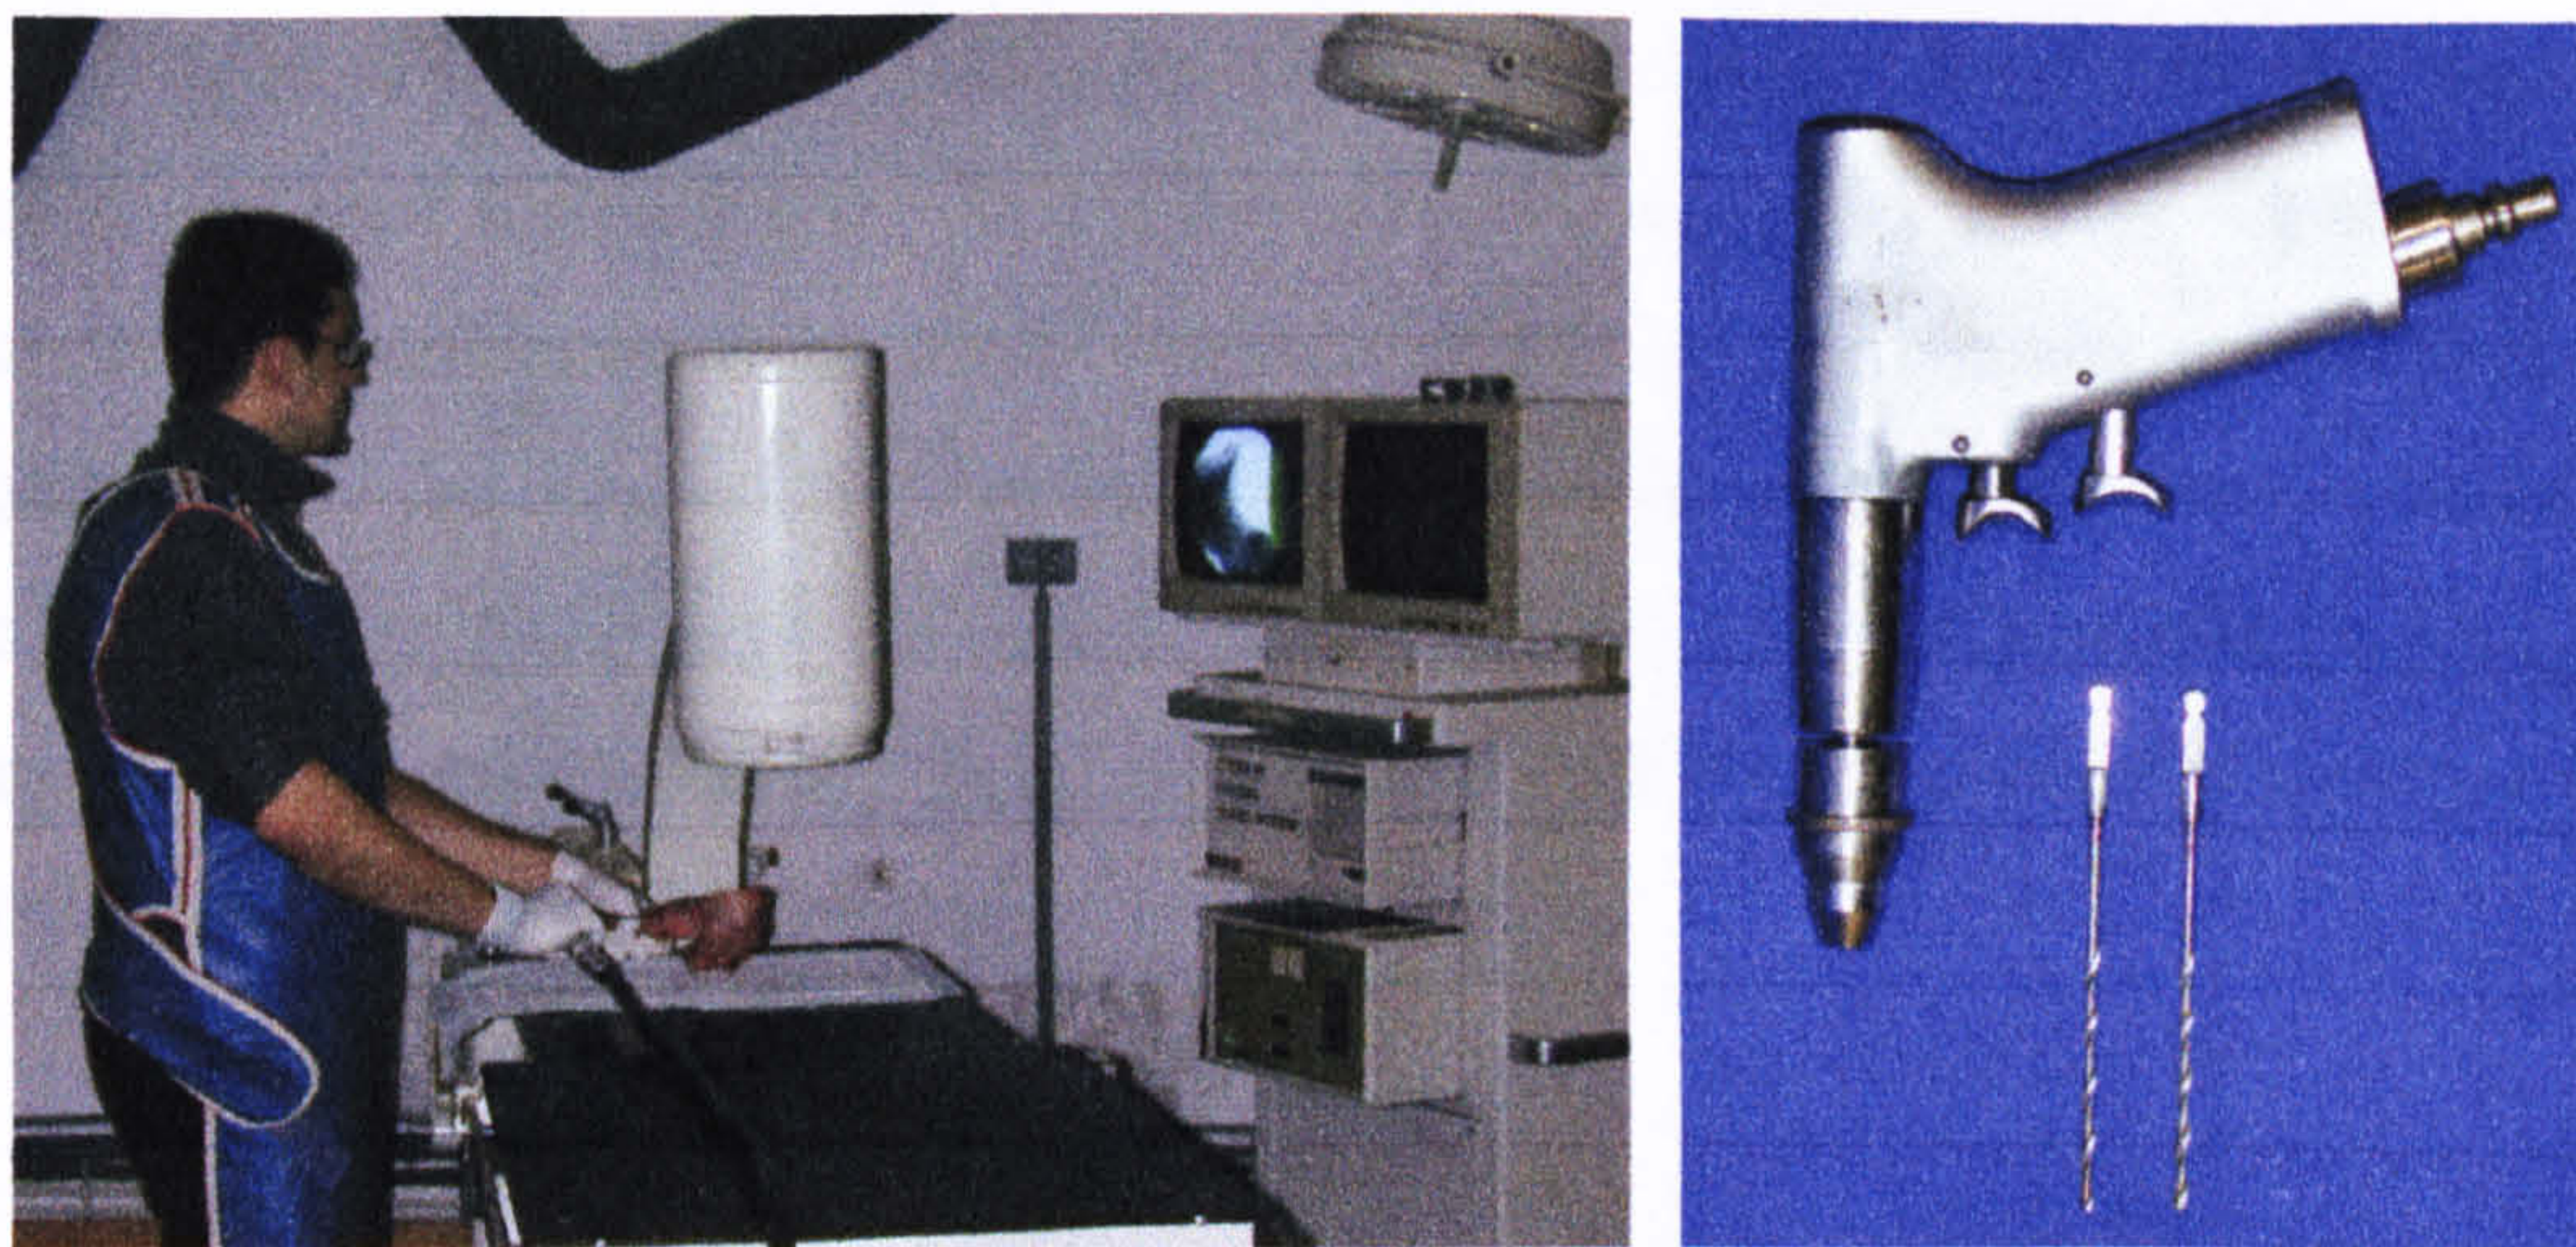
a and b Kirschner wires were inserted into the bone with x-ray visualisation. Pneumatic drills were used for opening the holes in the femur.
